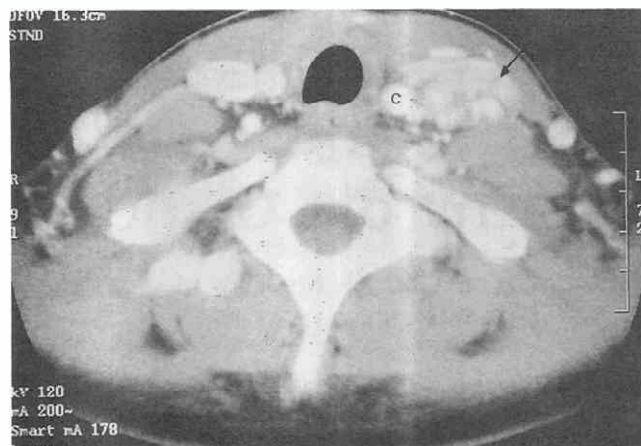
Axial postcontrast CT scan performed in a patient after thyroidectomy for papillary carcinoma. The heterogeneously enhancing mass (arrow) in the left neck lateral to the left common carotid artery (c) is consistent with a diagnosis of nodal metastasis.
